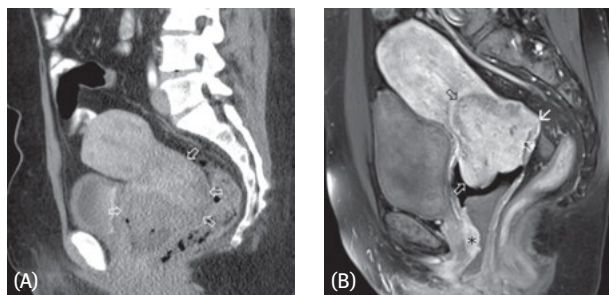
Comparison between a cervical botryoid rhabdomyosarcoma (A) in a 54-year-old patient, and a cervical carcinoma (B) in a 50-year-old patient; (A) abdominal sagittal CECT shows the significant degree to which the rhabdomyosarcoma has distended the vagina (bold arrows), further some air bubbles are visible within the tumor; (B) In contrast, sagittal T1 weighted MRI with i.v. administration of contrast agent plus fat suppression reveals no vaginal distension by the tumor (open arrows). Due to superior local resolution and soft tissue contrast compared to CT, MRI allows for more precise local staging. Here, infiltration of the posterior fornix and a drop metastasis on the anterior vaginal wall in the lower third of the vagina (star) are visible.
